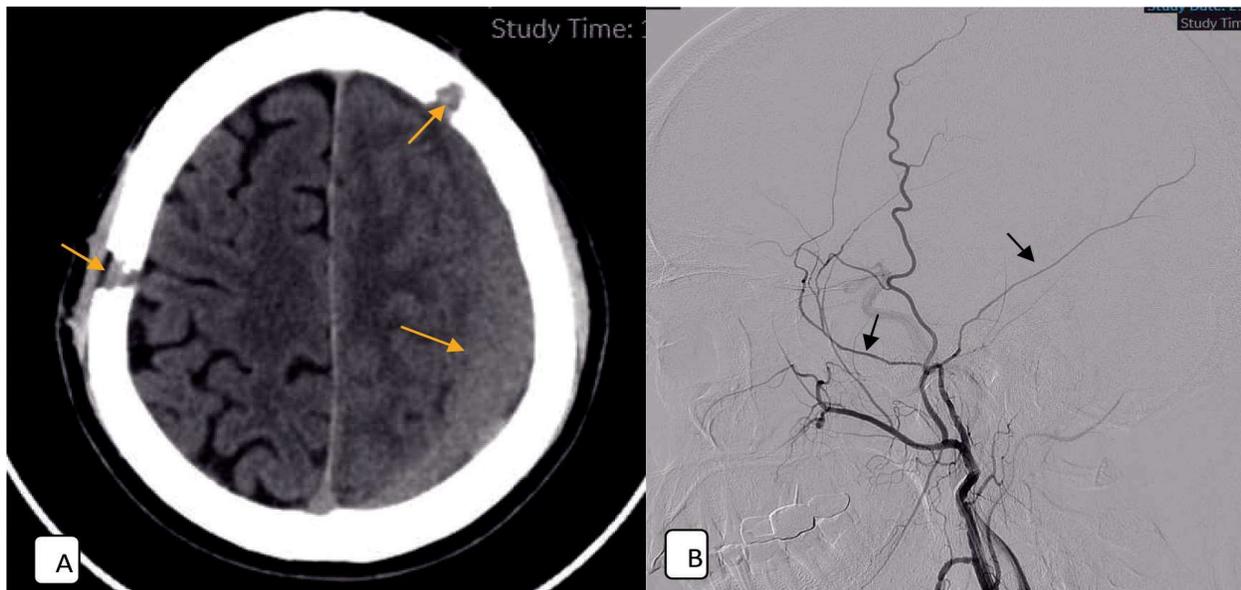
(A) CT axial image shows subacute to chronic SDH in left frontoparietal region with bilateral craniotomy (B) Left ECA angiogram shows middle meningeal artery
